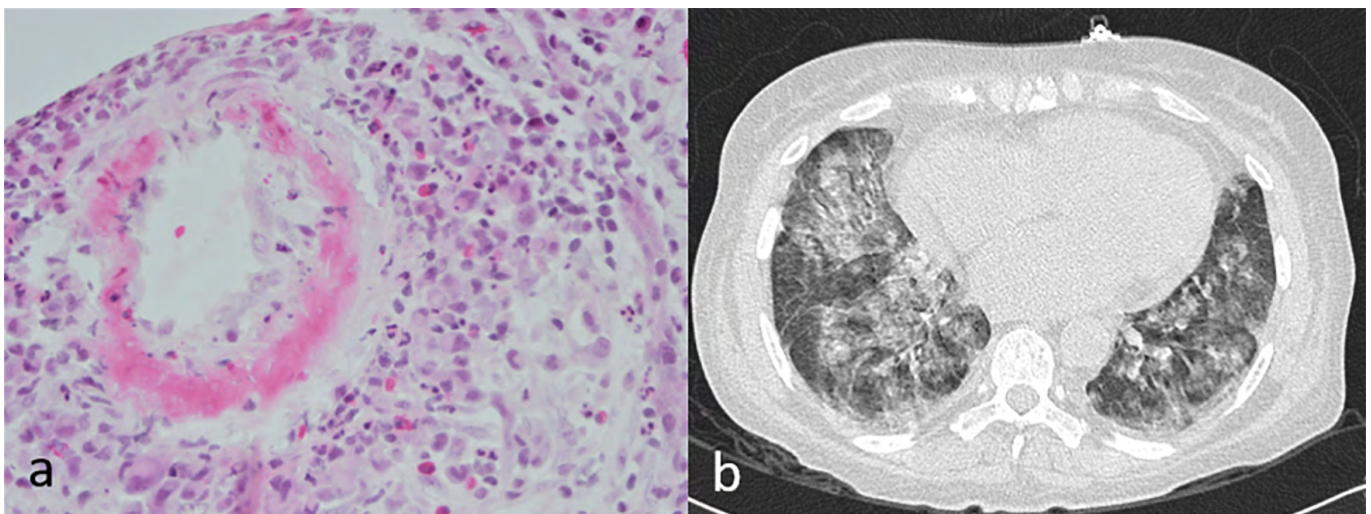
a) Renal biopsy: fibrinoid necrosis in the wall and karyorrhexis with acute inflammatory component in the periphery. b) Lung CT: ground glass and consolidative foci.
